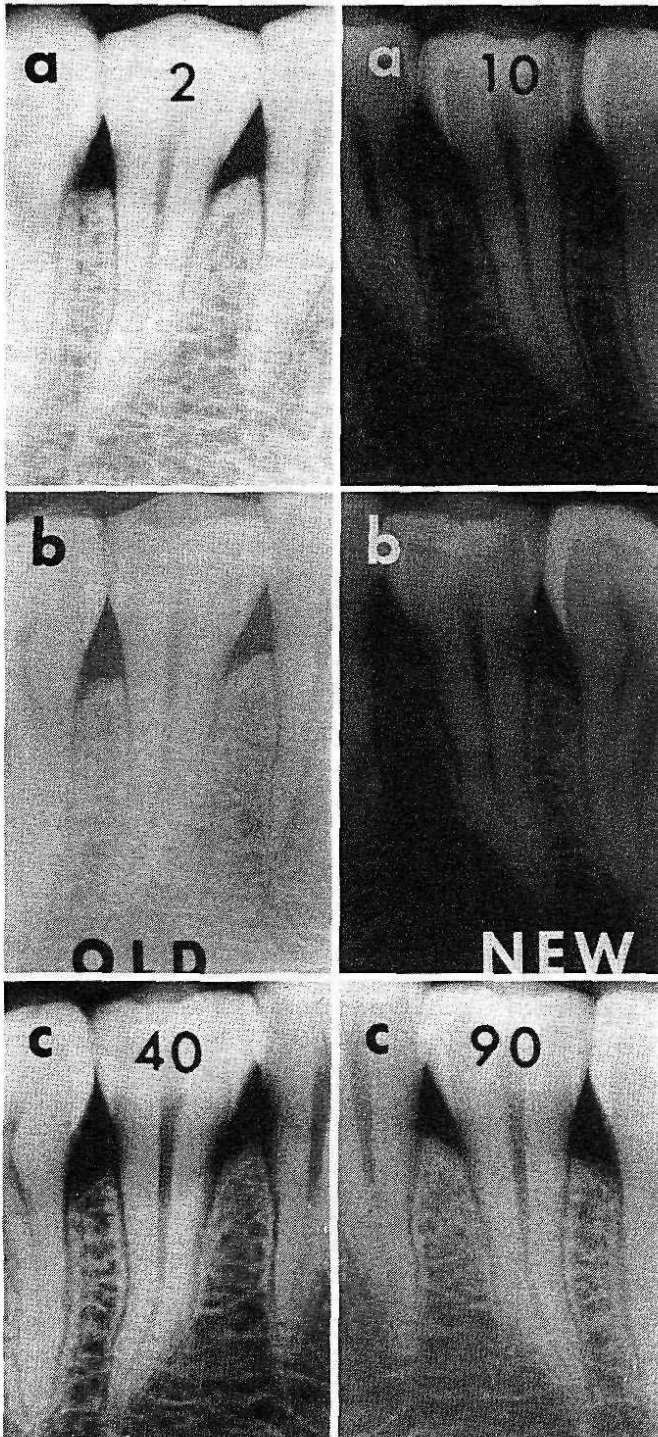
Technical aspects of intraoral radiography.
